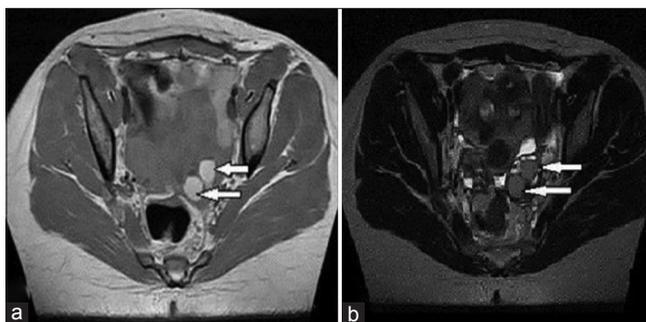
Magnetic resonance imaging of the pelvis showing axial images at the level of the left ovary. (a) T1-weighted image. (b) T2-weighted image. Multiple (two) oval masses in the left ovary (white arrows) seen. Note the shading sign phenomenon in the two images
